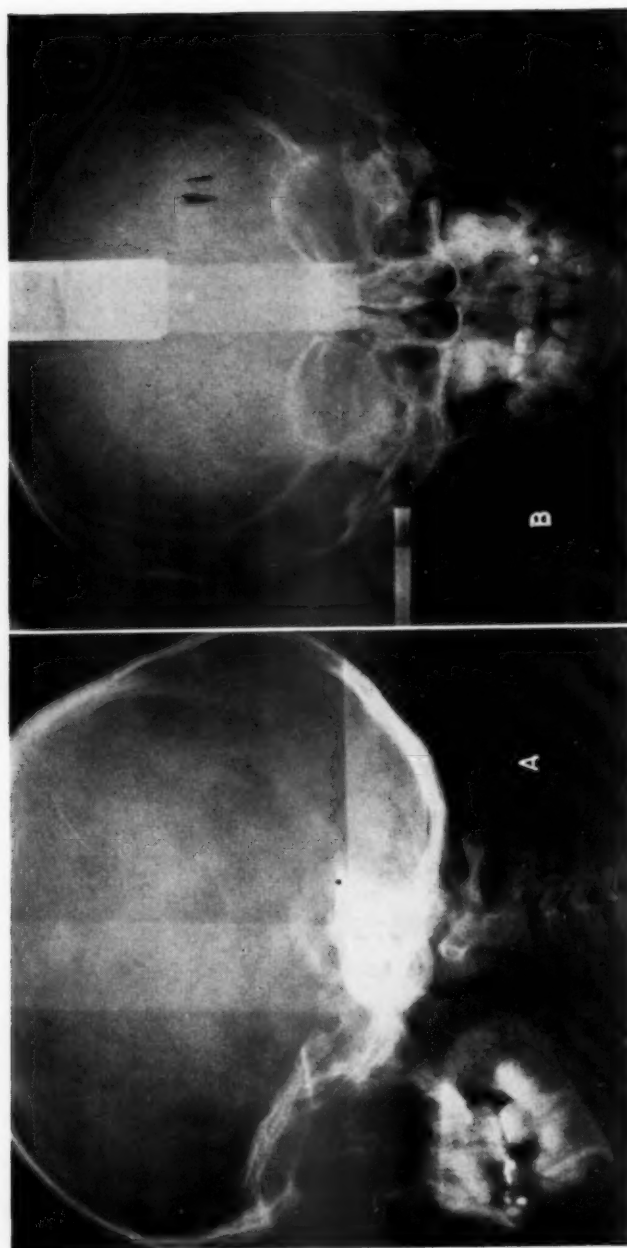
The pituitary dwarf (W. T.). The skull roentgenograms of W. T. Note small sella turcica and generally small facial bones.
